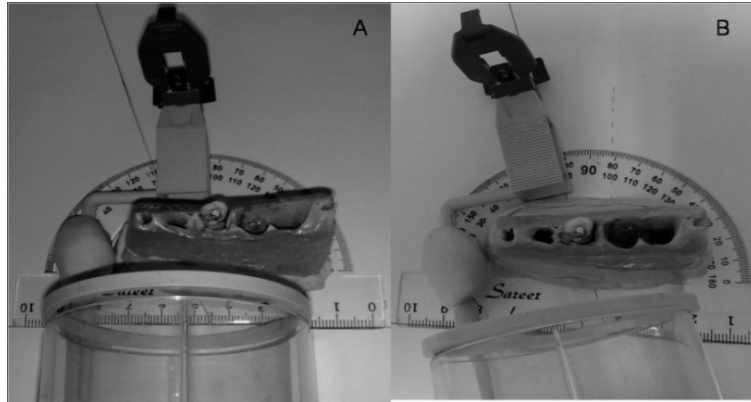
Radiographs were obtained from teeth in dried bone. A: Zero degree horizontal angulation (orthoradial). B: 15° distal angulation (distoradial)
